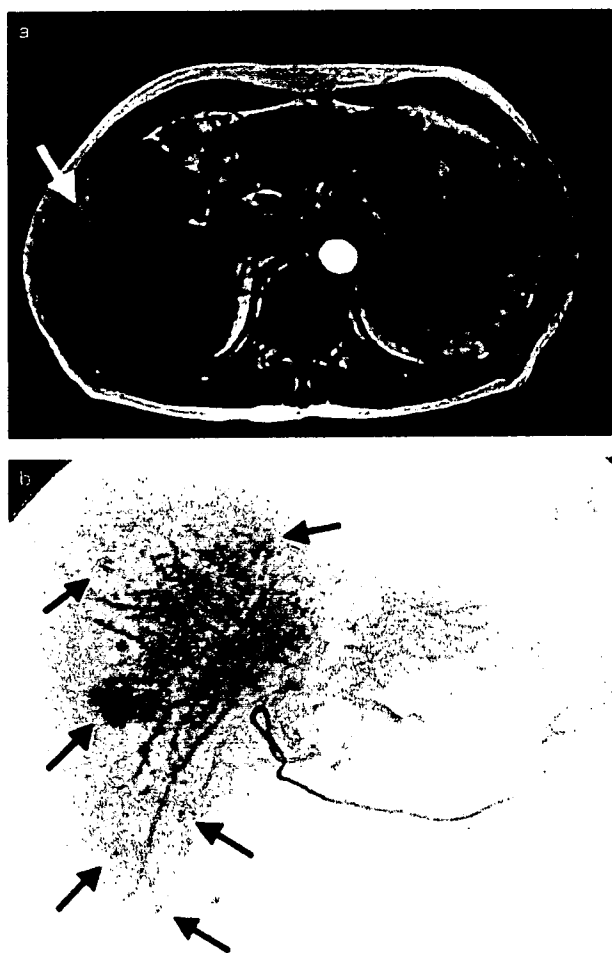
(a) Dynamic magnetic resonance imaging study of a 59-year old, male outpatient revealed a solitary tumor in the right lobe of the liver (white arrow). However, (b) digital subtraction arteriography performed after hospitalization showed multiple small hepatocellular carcinoma nodules throughout the right lobe (black arrows).
